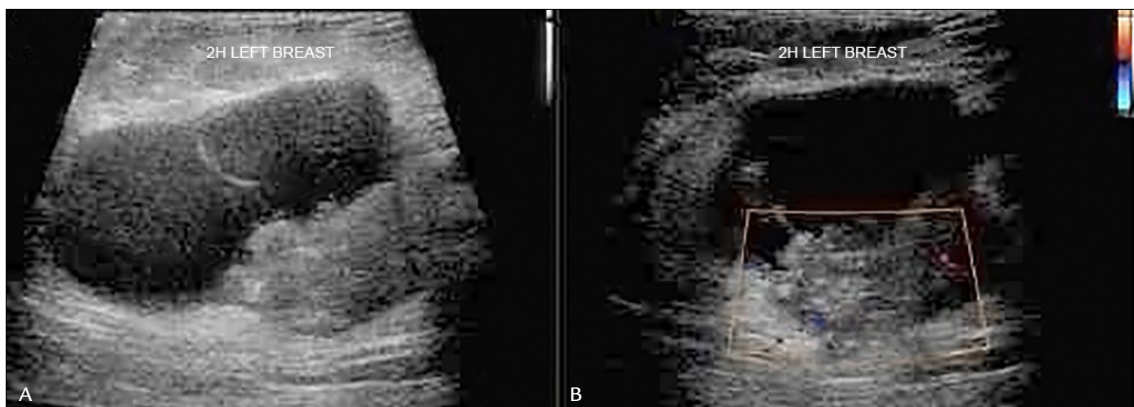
Ultrasound revealed a complex cystic and solid mass with internal vascularity on color Doppler, located in the upper-outer quadrant of the left breast.
